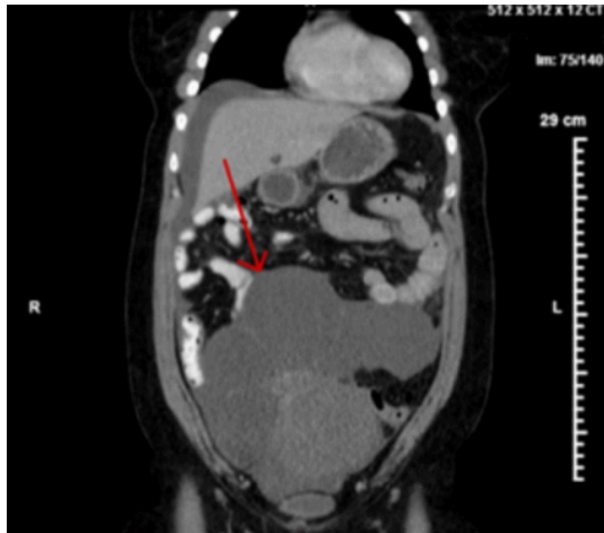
Abdominopelvic CT scan showing a large, 20.5 cm multi-lobulated cystic mass with calcified soft tissue component extending to the right adnexa (red arrow).
